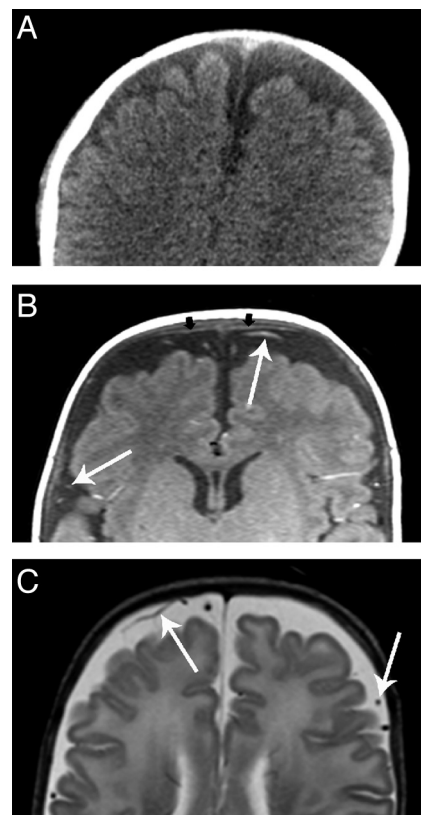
Benign enlargement of the subarachnoid space. While in CT (A), BESS could be misdiagnosed as SDHy, MR imaging (B, T1-weighted image; C, T2-weighted image) clearly demonstrates the presence of BESS. Note the vessels (thin arrows) spanning through the subarachnoid space. The small black arrows in B point at the subarachnoid membrane.
